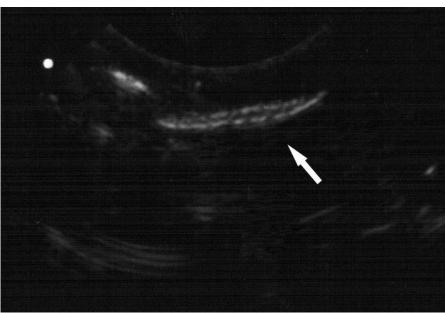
Ultrasonographic image of the Trematoda *Fasciola hepatica* isolated in acoustic gel, demonstrating a curvilinear aspect with hyperechogenicity at the periphery and an internal hypoechoic portion (arrow).
